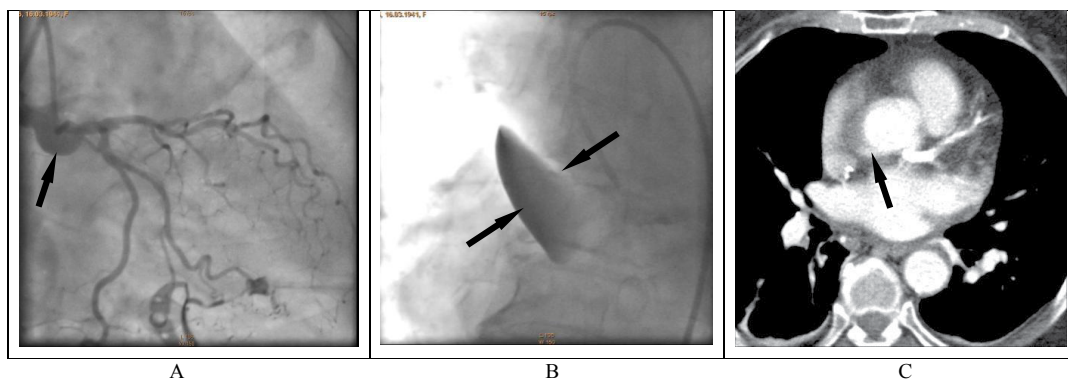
Visualization of the dissection. A - dissection beginning from the LM coronary artery and extending to the left sinus of Valsalva; B - screening of the ascending aorta reveals a localized dissection with the contrast medium retention within the false lumen (space between two arrows); C - plain computed tomography scan show an aortic dissection in the ascending aorta (arrow)
